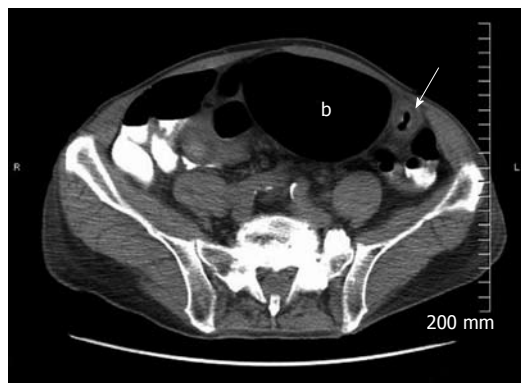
Computed tomography of the abdomen demonstrating circumferential thickening of a long segment of the distal colon (marked with white arrow) with a proximal dilated segment (marked with “b” inside the lumen of the dilated segment).
